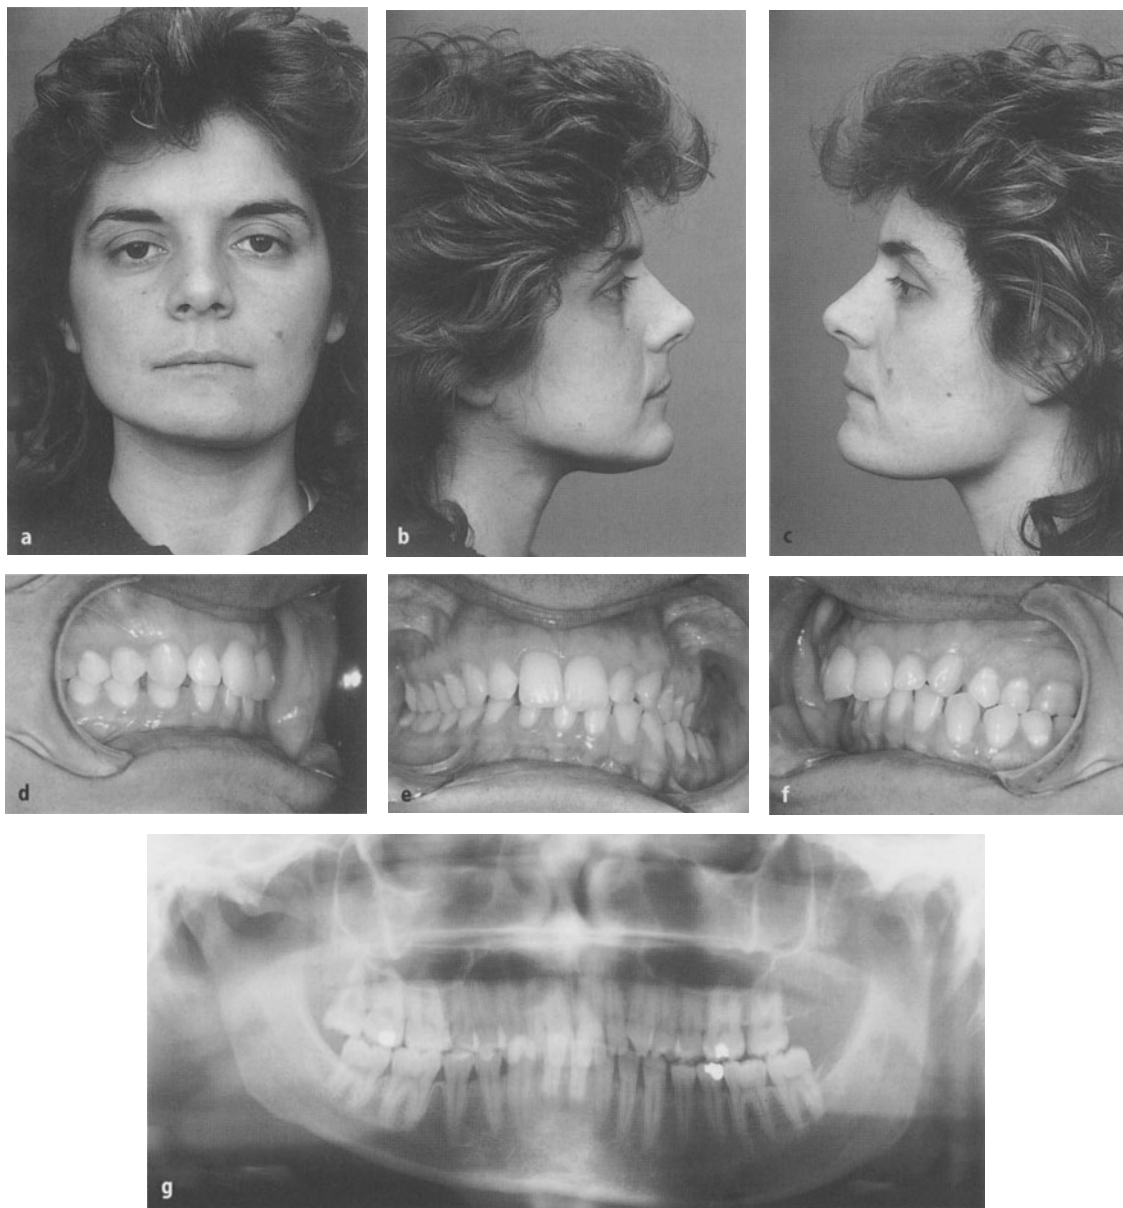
Unilateral highly active H.H. commencing after general growth has ceased and contralateral inactive slight H.E. a–c The patient's front and profile appearances showing the typical signs of a left H.H. and a right H.E. (the chin is deviated to the H.H. side). d–f The occlusion also permits the diagnosis of a right side H.E. and a left side H.H. g The panoramic radiograph permits the diagnosis of an unilateral H.H. and a contralateral H.E.
